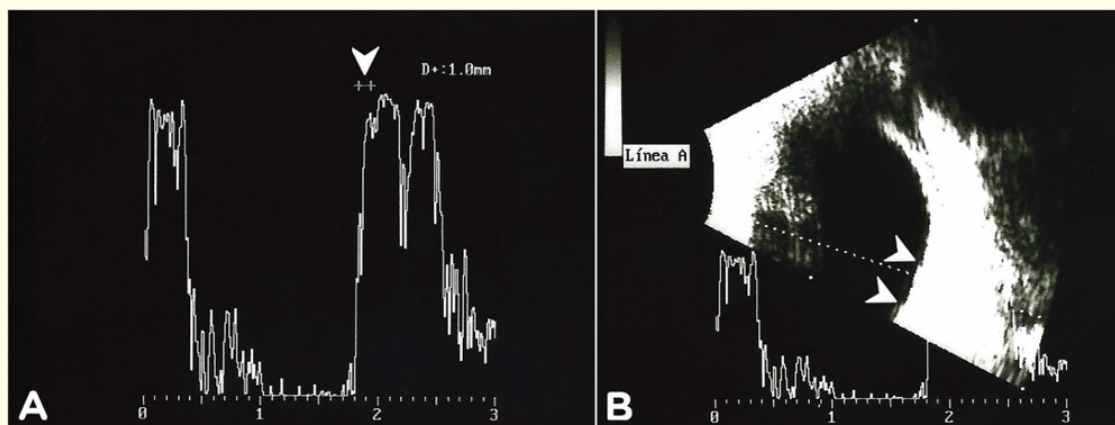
A) A-scan ultrasonography of the left eye showing a lesion with high reflectivity measuring 1mm in thickness (arrowhead). B) B-scan ultrasonography shows a slightly elevated small lesion (between arrowheads) with a basal diameter of 1 mm and absence of posterior acoustic shadow and calcifications. (Courtesy of Dr. Daniel Salas).
